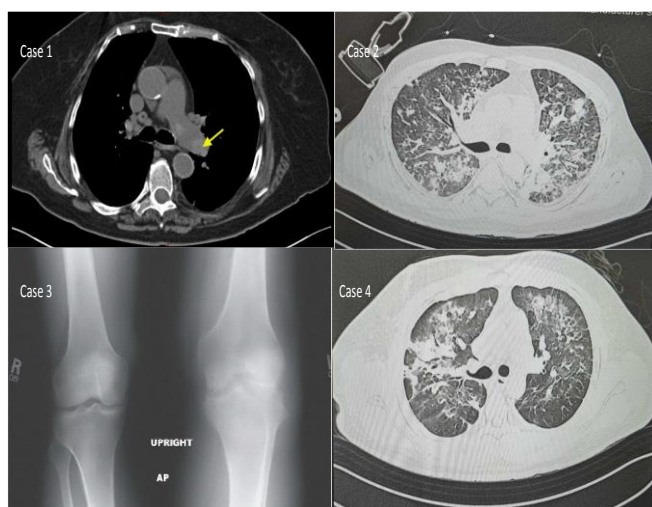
Radiological findings of patients: Case 1: Computed tomography pulmonary angiography showing pulmonary embolism; Case 2: HRCT showing features of consolidation; Case 3: X-ray of the right knee showing soft tissue swelling, edema, and capsular distension; Case 4: HRCT showing ground-glass opacity, consolidation, and interlobar septal thickening.
